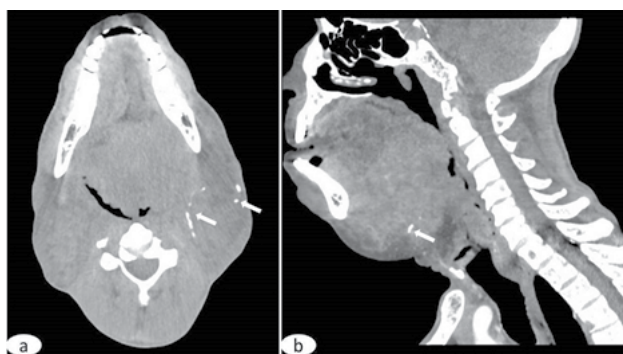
(a) Axial and (b) sagittal CT scan of the neck showing a huge ill-defined heterogeneous predominantly isodense mass in the bilateral submandibular region more to the left and extending superiorly to the floor of the mouth. Curvilinear calcifications were also observed (arrows).
